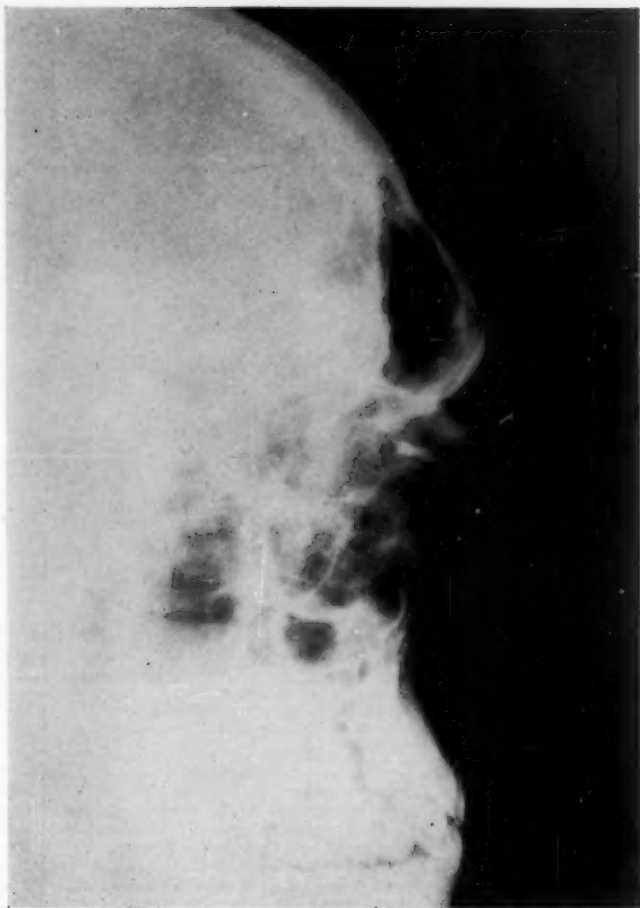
Roentgenogram made after injection of iodized oil. The posterior extension is not visualized because the contents of the cyst obstructed its flow.
